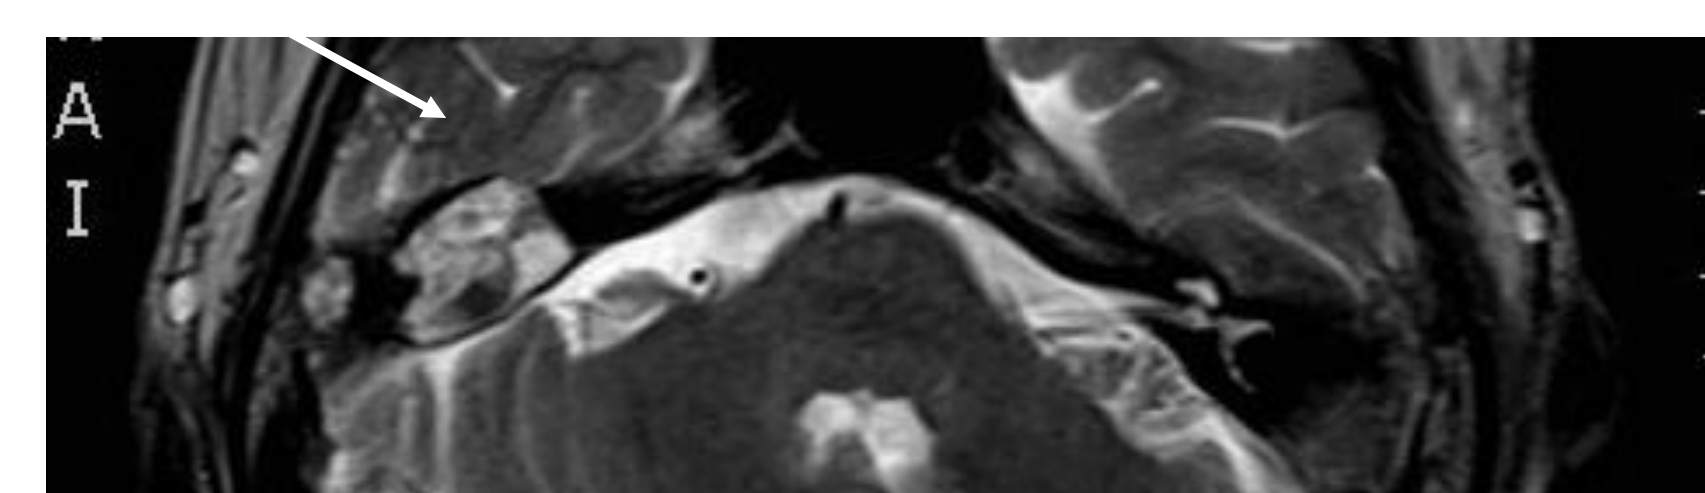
Axial T2 MRI of patient 1, had the only suspicious area (arrow) that the radiologist ignored likely due to previous surgery considering it fluid in the mastoid.
